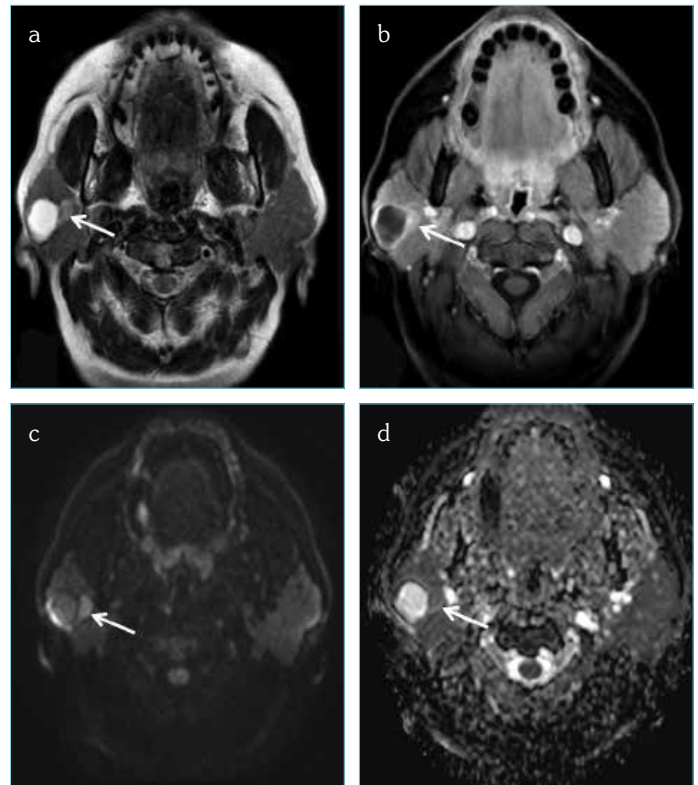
a-d. MRI of 43 year old female presented with right parotid swelling. Axial T2 weighted MR image (a), contrast enhanced T1 with fat suppression (b), DWI (c) and ADC map showed (d); Well circumscribed lesion with peripheral nodular enhancing soft tissue component "white arrow" is seen involving the superficial lobe of the right parotid gland. The lesion displays high T2 signal and irregular peripheral enhancement in the post contrast series. Large non enhancing central area of fluid signal is seen representing area of breaking down. The irregular nodular peripheral enhancing area "white arrow" appears high in DWI and low in ADC map denoting restricted diffusion pattern, while the non-enhancing central portion shows high signal in DWI and ADC map denoting T2 shine through. ADC value measures: $0.756 \times 10^{-3} \text{ mm}^2/\text{sec}$. Pathological evaluation revealed mixed salivary tumor "carcinoma ex-pleomorphic adenoma"
